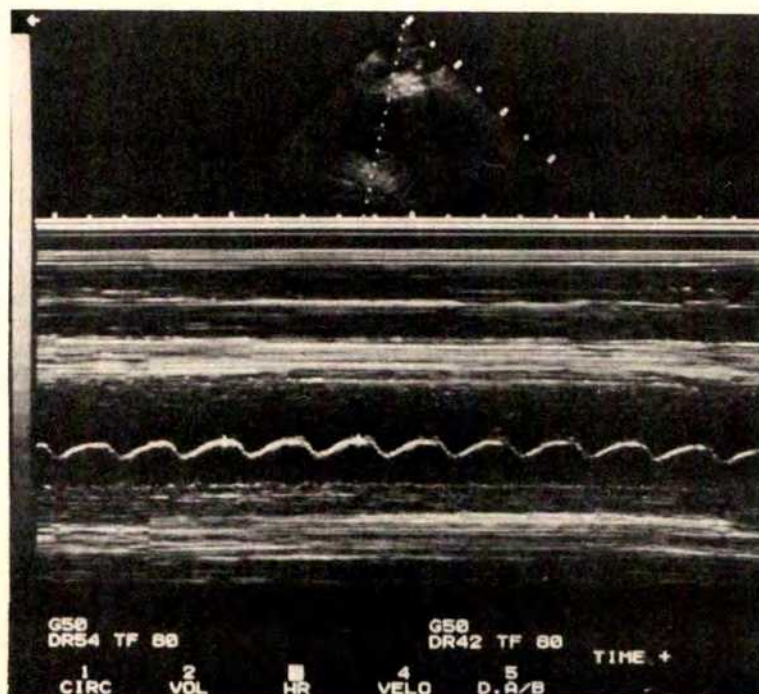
M-mode echocardiography after hydralazine discontinuation.
